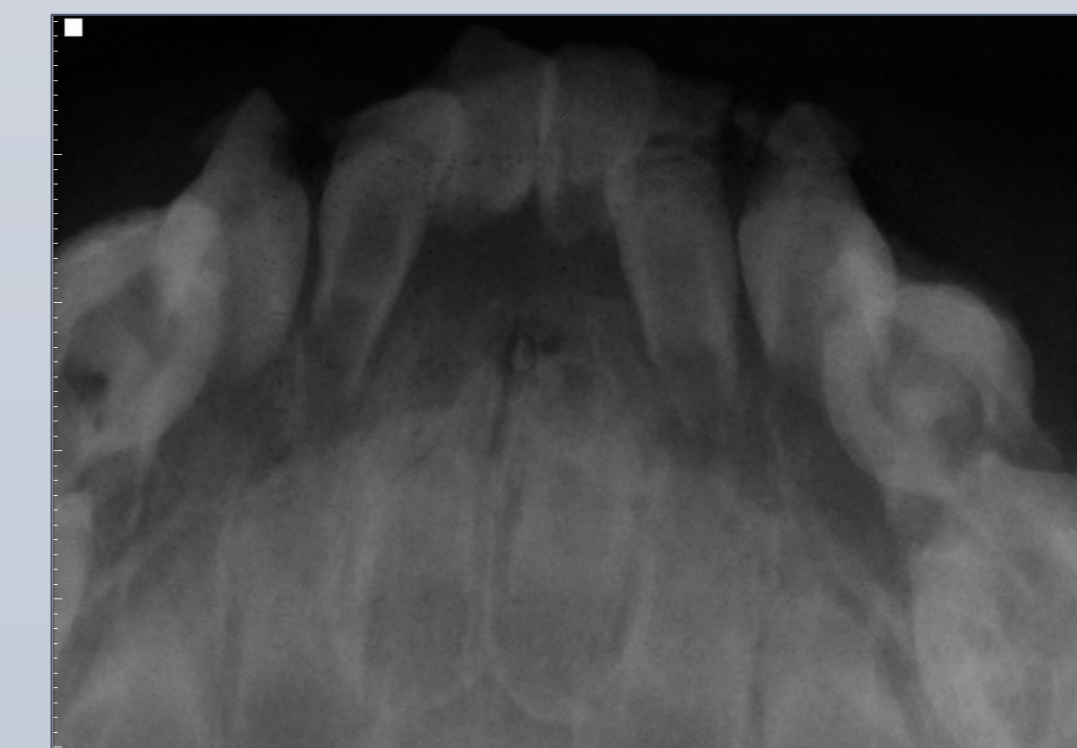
Mandibular Periapical 12/21/2016
